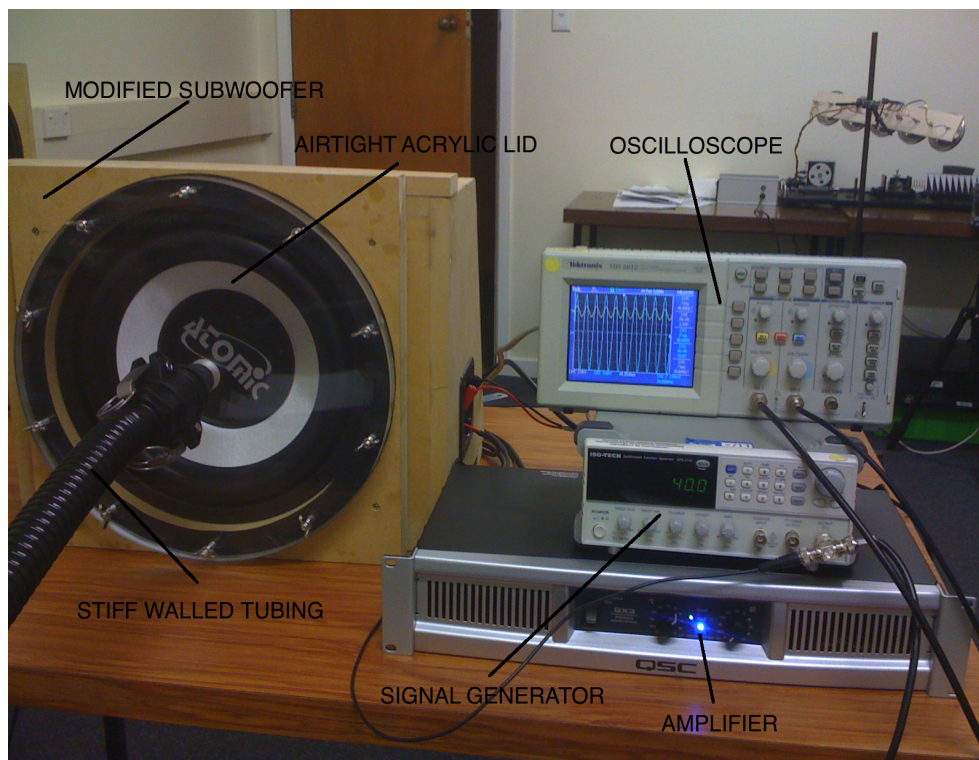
Experimental set up of the acoustic brain actuator. A signal generator is connected to an amplifier through a two channel oscilloscope. One channel is connected to a passive subwoofer used to generate acoustic pressure waves and drive pneumatically actuated drivers (PADs). Another channelled is to be connected to an MRI scanner via an RS422 converter to allow synchronisation of induced mechanical motion with MRI image acquisition to allow motion encoding.
